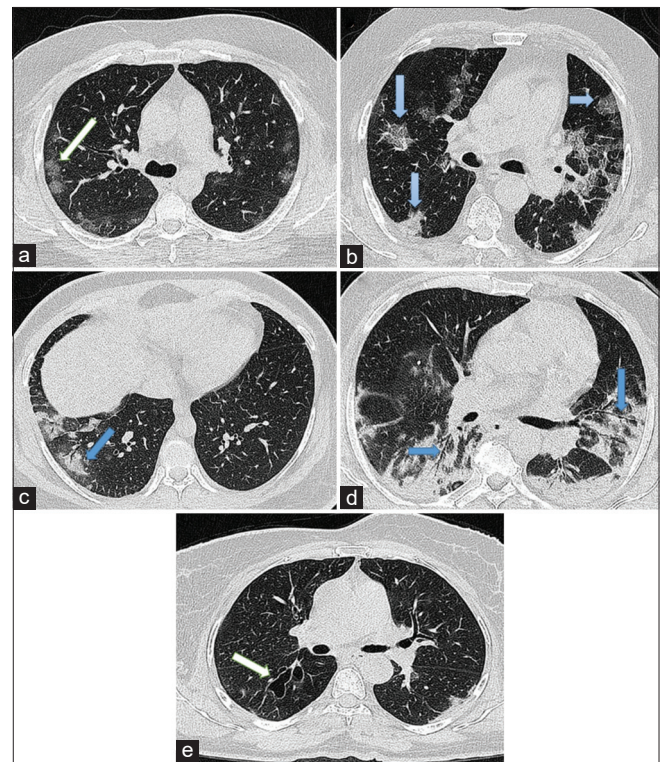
High resolution chest CT features indicating lung changes caused by SARS-CoV-2 pneumonia in five cases. (a) Axial CT image obtained without intravenous contrast injection in a 48-year-old man demonstrates bilateral ground-glass opacities in upper lobes with a rounded morphology (white arrow). (b) Axial CT image obtained in a 67-year-old man shows bilateral ground-glass and consolidative opacities with a peripheral distribution (blue arrows). (c) CT image in a 25-year-old woman reveals consolidative changes in right lower lobe, while left lung was normal (blue arrow). (d) CT image obtained in a 57-year-old man 9 days from symptom onset shows airbronchogram with bilateral lung involvement in both lower lobes (blue arrows), subpleural line in right lung is evident. (e) Axial CT image in an 80-year-old woman exhibits bronchiectasis associated in right lower lobe on day 11 after onset of symptoms (white arrow)
